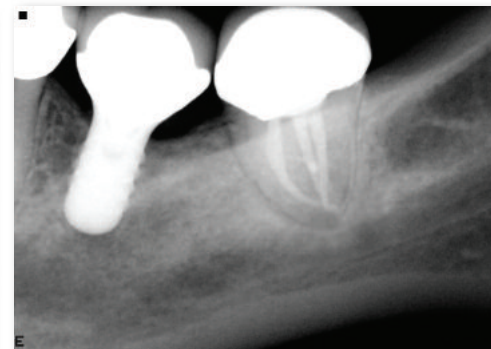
A postoperative radiograph six months later demonstrates periradicular healing following successful root canal treatment.
